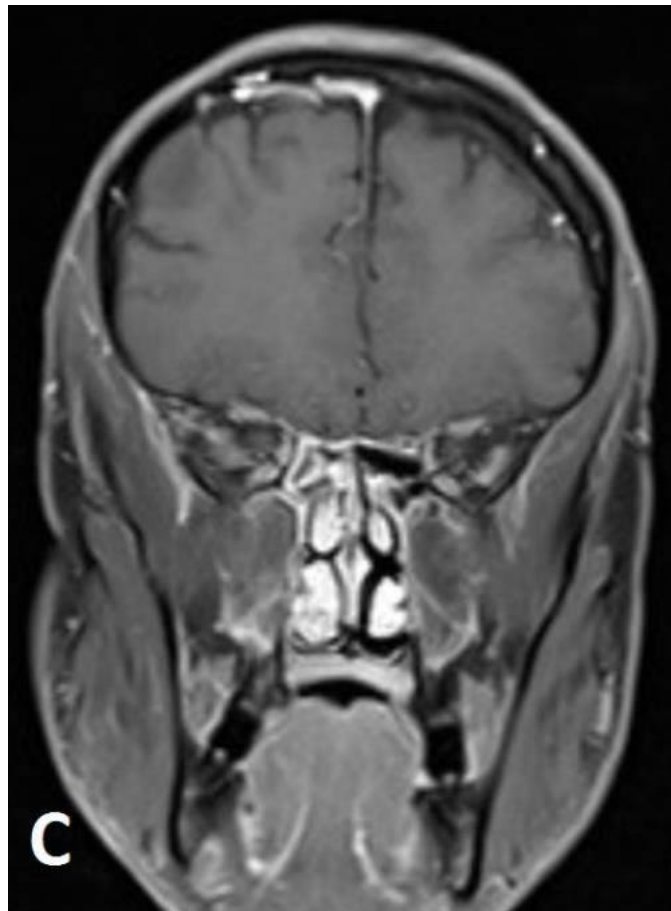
Figure C T1-weighted coronal post contrast MRI.
